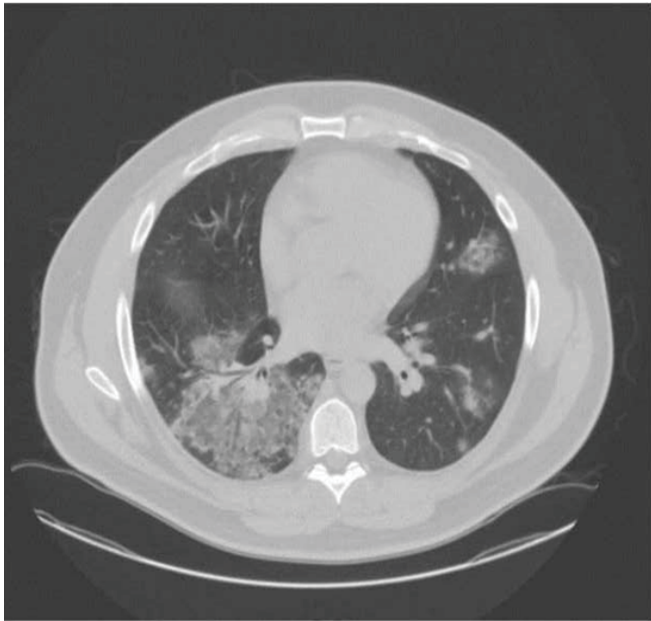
CT scan of the chest demonstrating multifocal pneumonia and peri-bronchial and perivascular interstitial infiltrates. A CT of the chest was performed in the course of further diagnostic evaluation. CT of the chest revealed bilateral multifocal mixed ground-glass/solid airspace opacities, but no pleural effusion, pneumothorax, or pleural thickening.
